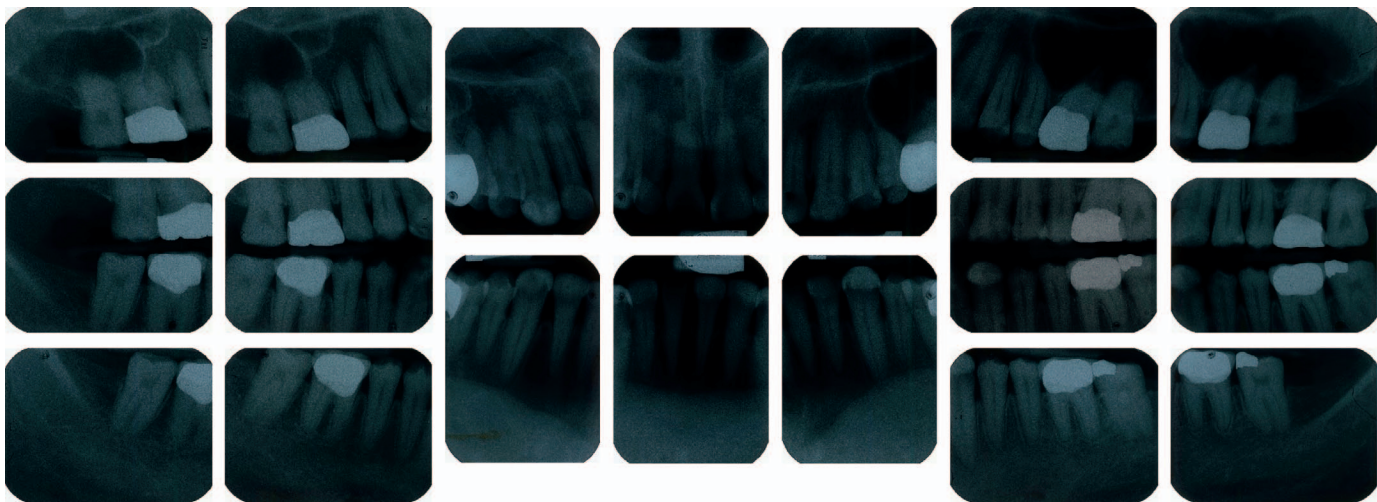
Full-mouth periapical radiograph.
